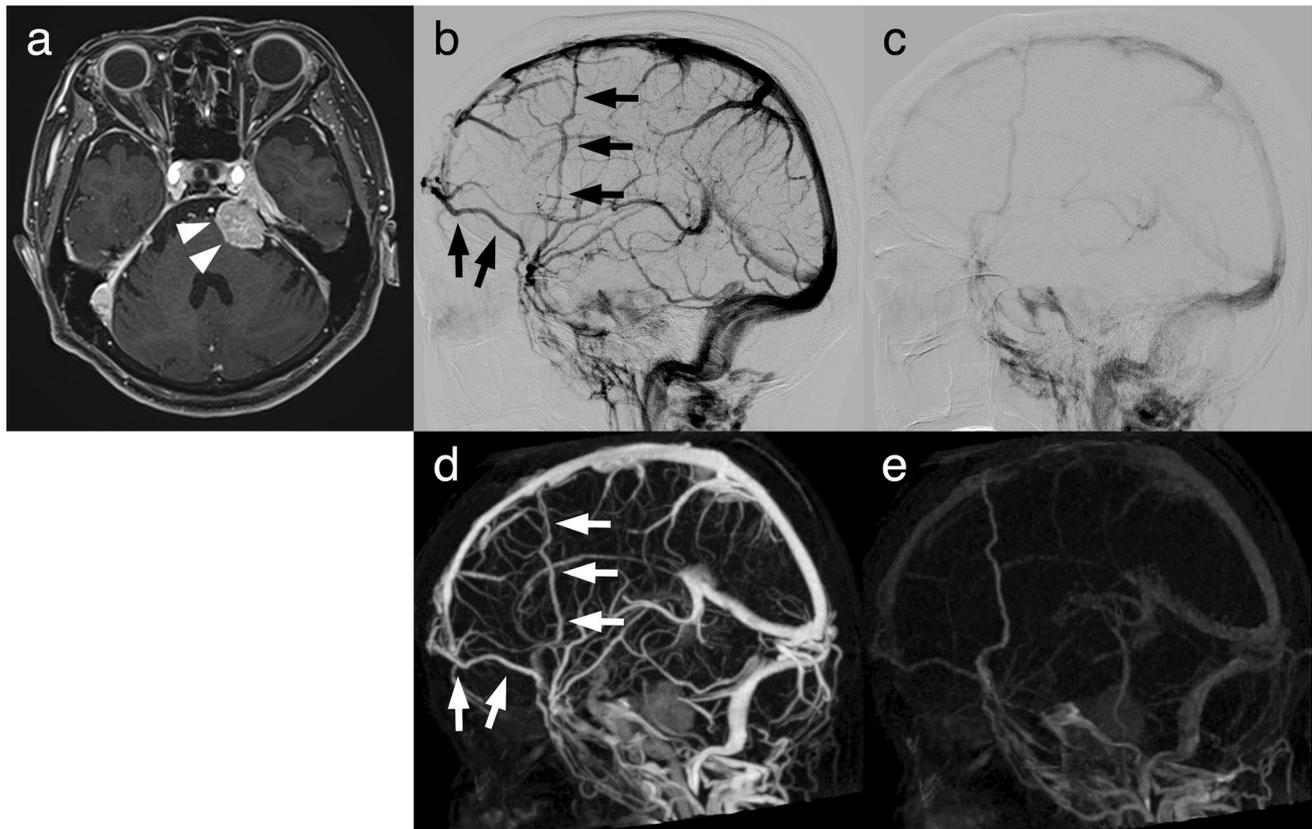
Representative case of the early type diploic vein. Contrast-enhanced magnetic resonance imaging displaying left side petroclival meningioma (a). On the preoperative internal carotid artery angiography, the early-type diploic veins are concurrently visualized with venous sinuses (b) and simultaneously disappear with the venous sinuses (c). These findings are consistent with those of time-resolved
